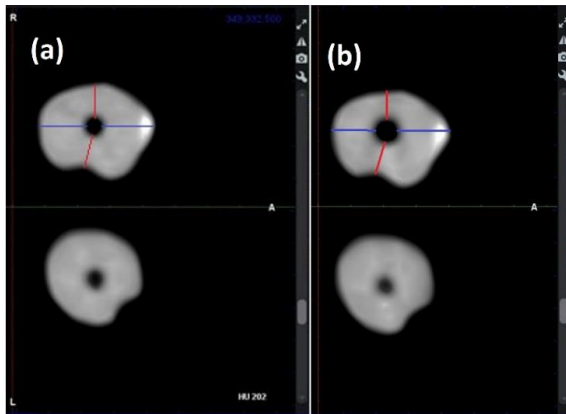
Cone beam computed tomography image of root canal axial cross-section. (a) Shows pre-instrumentation and (b) shows post-instrumentation. Red and blue lines represent the shortest distance from the inner wall of the root canal to the root boundary in bucco-lingual and inner-outer of curvature directions, respectively
